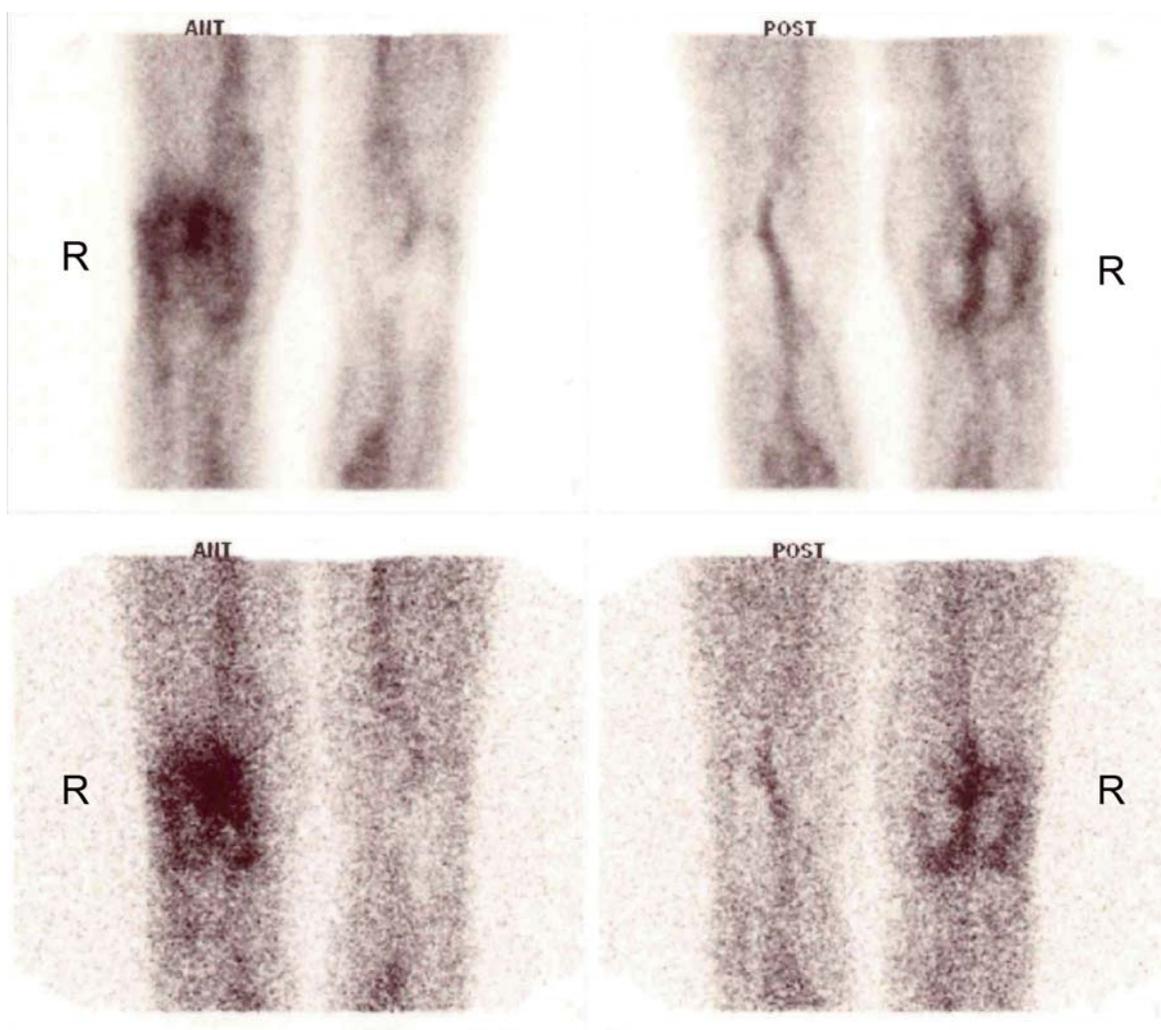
Anterior (left) and posterior (right) labelled leukocyte images of the patient showing increased periprosthetic activity around right total knee replacement with ^{99m}Tc -HMPAO-labelled leukocyte scintigraphy. R, right; Ant, anterior; Post, posterior; images acquired at 2 different time points: 1 h (upper images) and 24 h (lower images).
